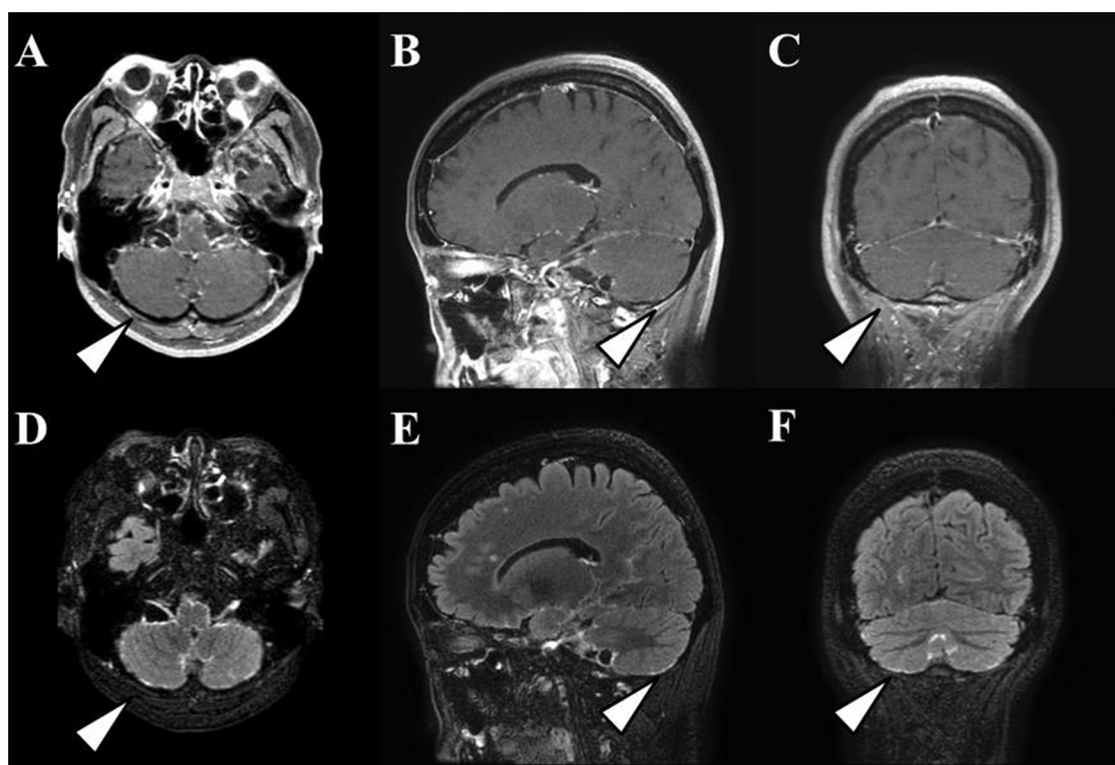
Brain magnetic resonance imaging. Unlike three-dimensional (3D) contrast-enhanced (CE)-Cube T1-weighted imaging (A–C), 3D CE-Cube FLAIR imaging (D–F) revealed possible bilateral cerebellar leptomeningeal lesions. Arrowheads indicate the biopsied leptomeningeal lesion.
